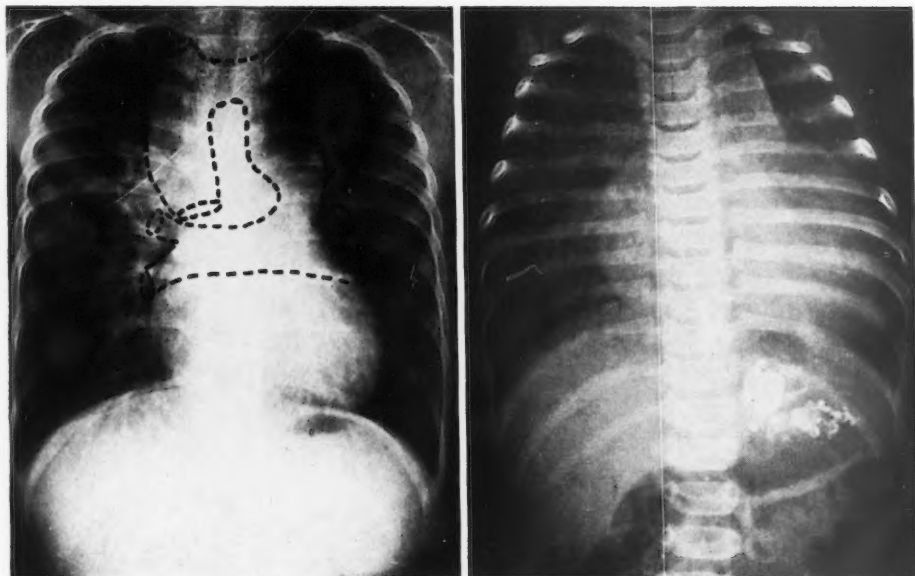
Left*. Roentgenogram of chest in child with typical figure-eight mediastinum considered diagnostic of total anomalous pulmonary venous return into left innominate vein (case 7). Dotted lines indicate anticipated location of veins.
